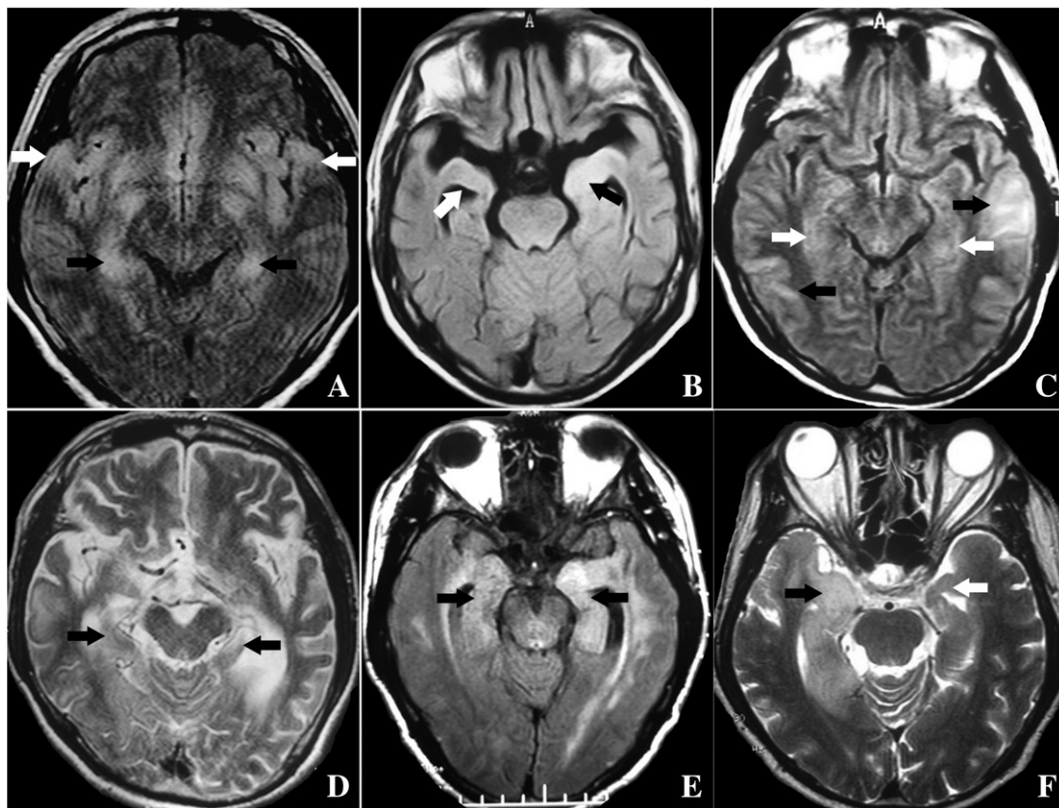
(A) Axial FLAIR image of Patient 1 showing bilateral hyperintensities in the mesiotemporal lobes (white arrows), including the hippocampi (black arrows). (B) Axial FLAIR image of Patient 2 showing a hyperintensity in the left hippocampus (black arrow) and atrophy in the right hippocampus (white arrow). (C) Axial FLAIR image of Patient 3 showing bilateral hyperintensities in the hippocampi (white arrows) and temporal lobes (black arrows). (D) Axial T2-weighted image of Patient 4 showing bilateral hyperintensities in the hippocampi, brain atrophy, and bilateral hippocampal atrophy (black arrows). (E) Axial FLAIR image of Patient 5 showing bilateral hyperintensities in the hippocampi (black arrows). (F) Axial T2-weighted image of Patient 6 showing a hyperintensity in the right hippocampus (black arrow) and atrophy of the left hippocampus (white arrow).
